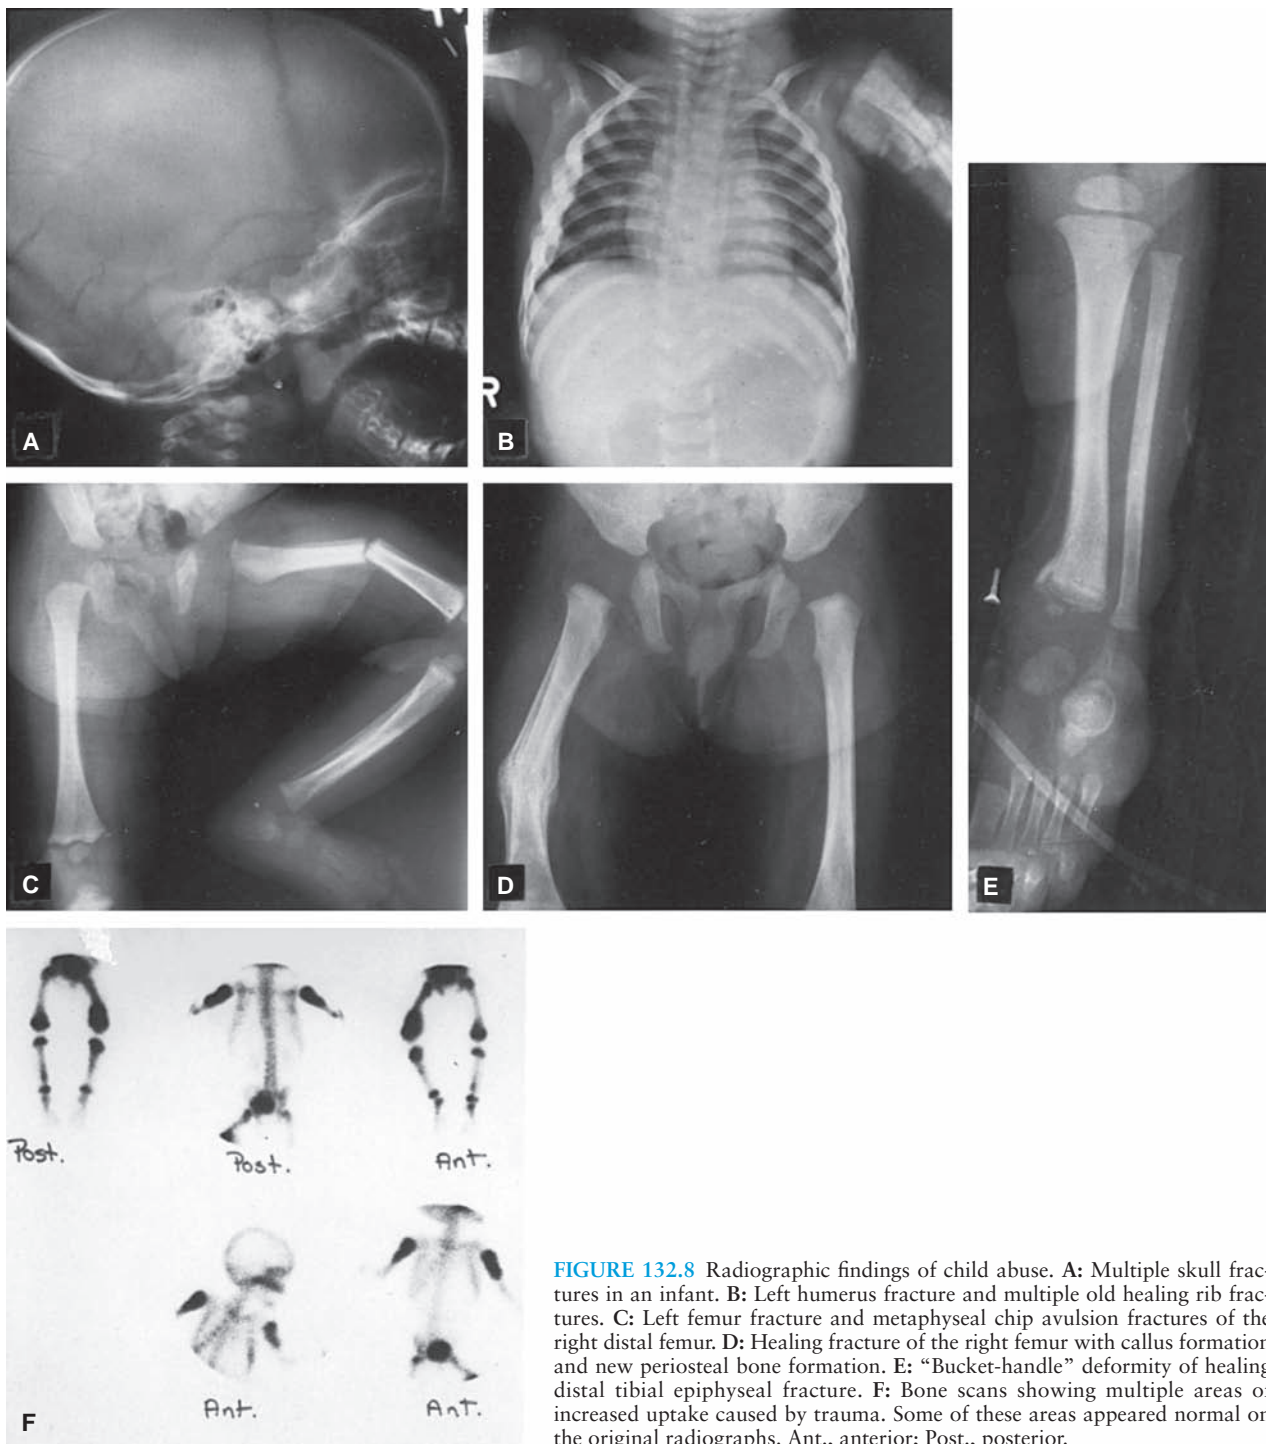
Radiographic findings of child abuse. A: Multiple skull fractures in an infant. B: Left humerus fracture and multiple old healing rib fractures. C: Left femur fracture and metaphyseal chip avulsion fractures of the right distal femur. D: Healing fracture of the right femur with callus formation and new periosteal bone formation. E: “Bucket-handle” deformity of healing distal tibial epiphyseal fracture. F: Bone scans showing multiple areas of increased uptake caused by trauma. Some of these areas appeared normal on the original radiographs. Ant., anterior; Post., posterior.
